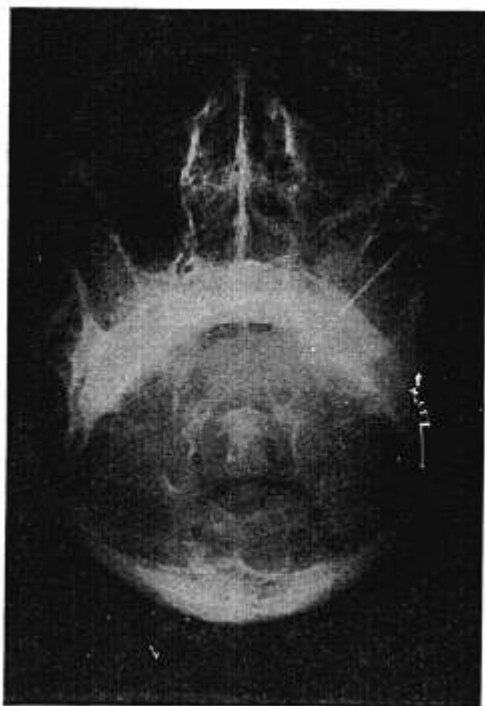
Roentgenogram of the skull of a patient who had cancer of the superior alveolus which invaded the left maxillary antrum and left orbital cavity. Relief was produced with left ganglionic ganglion block. Note clouding of the left maxillary sinus and also point of the needle in the foramen ovale.
